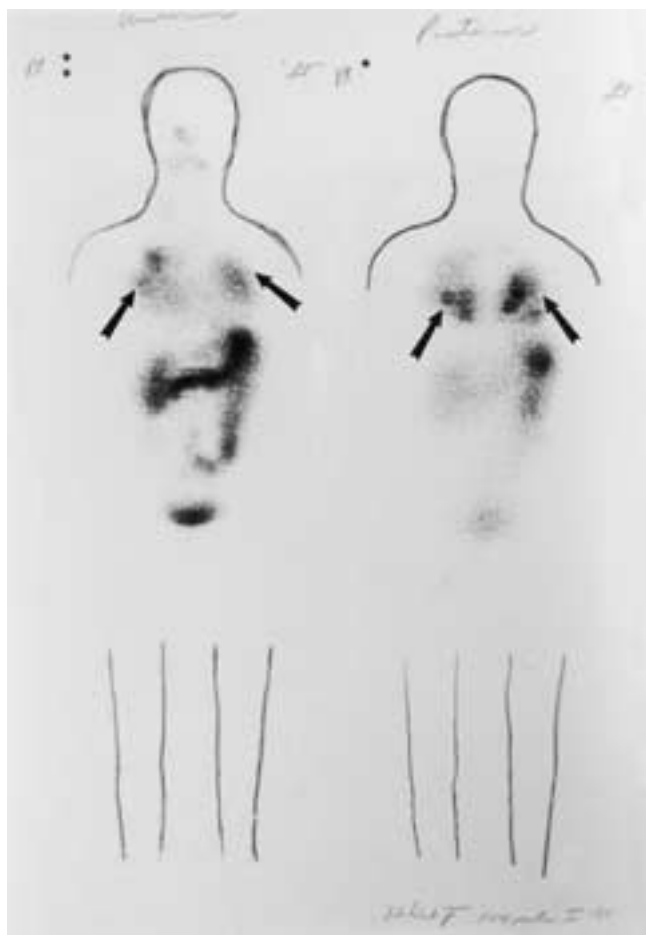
I-131 scintigraphy following thyroidectomy for papillary carcinoma. Whole body images obtained 72 hours after the administration of I-131 shows radiotracer uptake in diffuse lung metastases (arrows).
